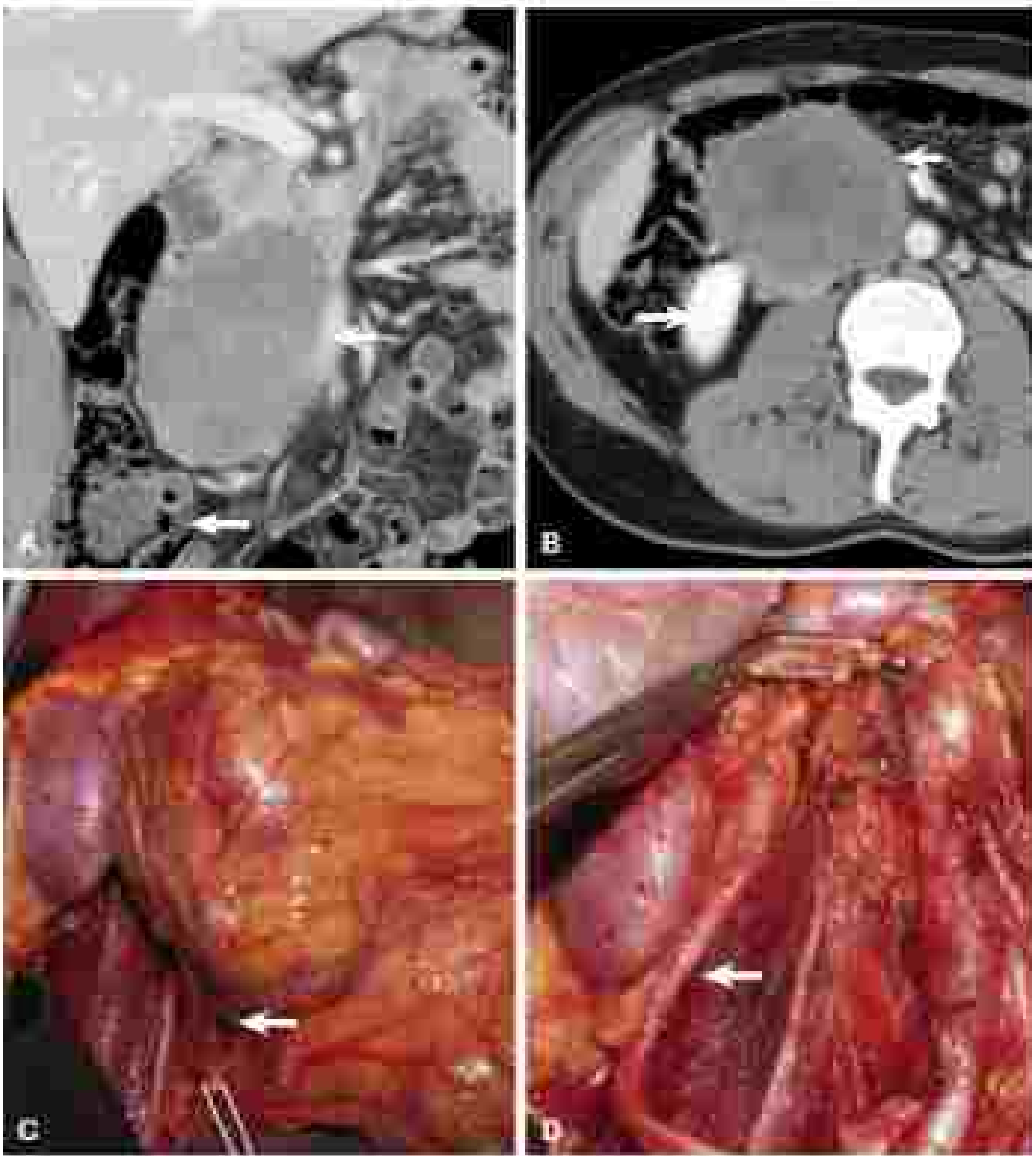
(A–B) Coronal/axial computed tomography images of a hemangioendothelioma of the inferior vena cava (left panel) displaying (A) right kidney and the right ureter (right panel), intraoperative image showing displacement (C, arrow) and preservation of the right ureter and kidney (D, arrow).
